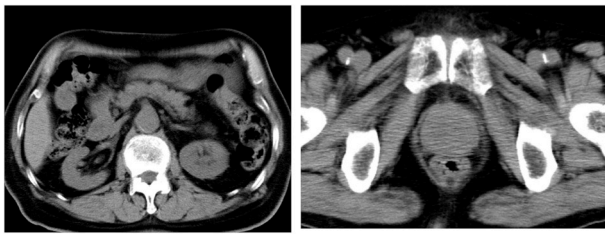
In 2015.9.16, Abdominal CT scan shows mild prostate hypertrophy and normal kidneys.
